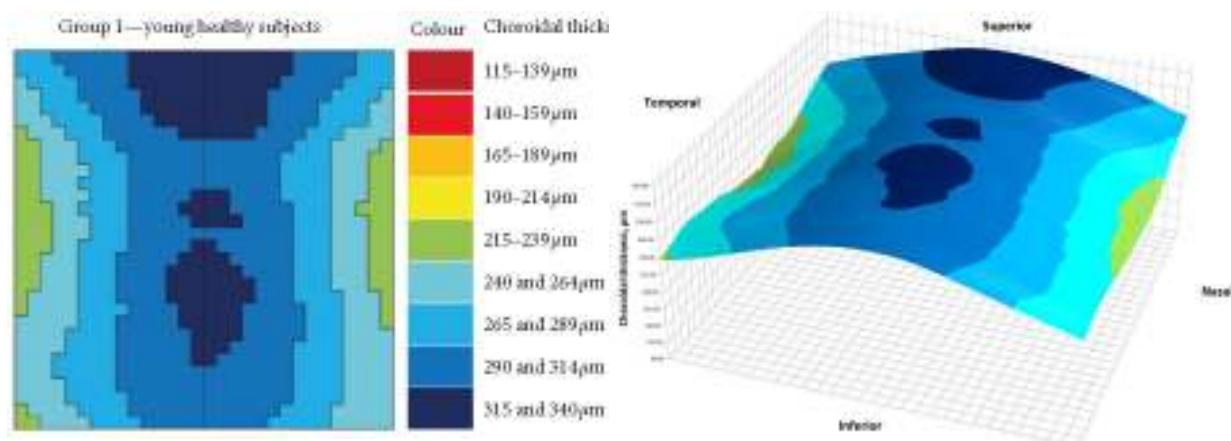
2D representation of CT in young healthy subjects.
